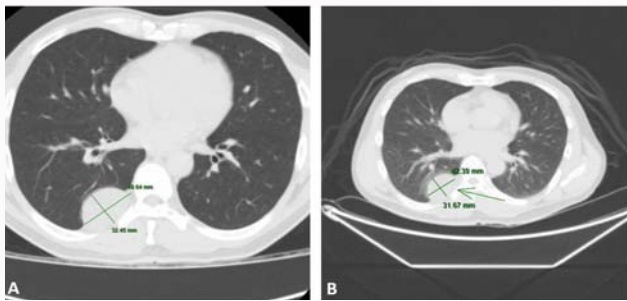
(A) CT chest showing a roughly 4.9 cm sharply-margined right pleural-based mass along the 8th rib. (B) FDG-PET showing a roughly 4.3 cm x 3.1 cm posterior mediastinal mass.
